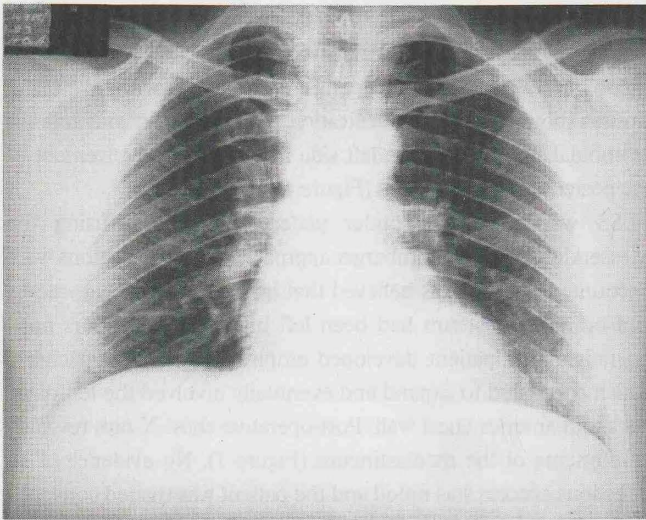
Chest X-ray two weeks post-operatively showing spontaneous resolution of the mediastinal emphysema.
